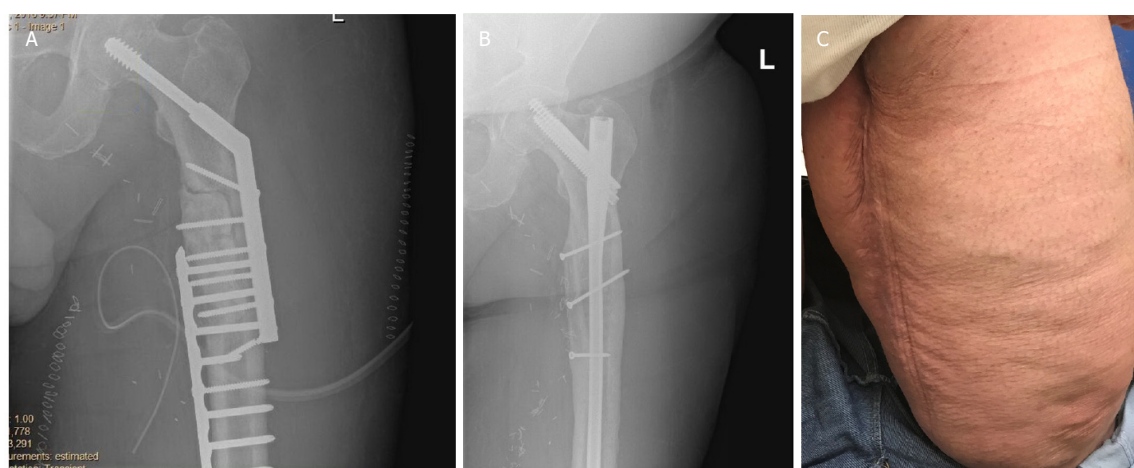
A: radiograph of case 5 before free fibula graft demonstrating nonunion; B: post operative radiograph of free fibula with IMN; C: two year follow-up with patient, who is ambulating and healing well
